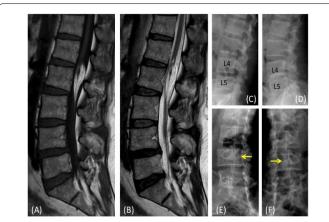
Case 2. Lumbar spinal magnetic resonance images. Preoperative sagittal and axial images showed a high intensity area at L2 on T1WI (A), T2WI (B). Preoperative roentgenokymograms indicated L4/5/S instability (C, D). Preoperative oblique roentgenograms revealed L4 isthmic spondylolysis (E, F) (yellow arrow).
